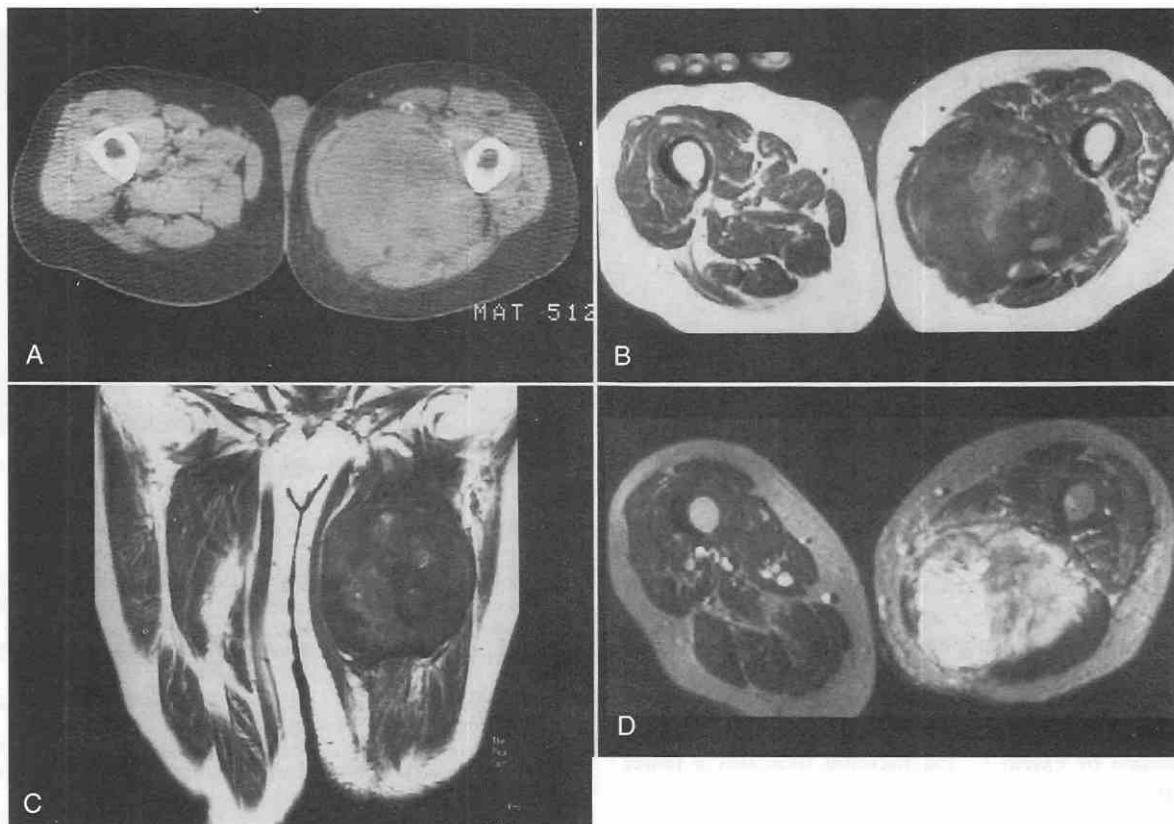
Well-differentiated liposarcoma. A, CT scan shows a large mass with heterogeneous density, suggesting that portions of this mass are necrotic, but fat density is not identified. B and C, Axial (B) and coronal (C) spin-echo images (TR = 600 msec, TE = 15 msec) show a large mass with heterogeneous signal; small foci with higher signal intensity may represent hemorrhage or fat within the tumor.
